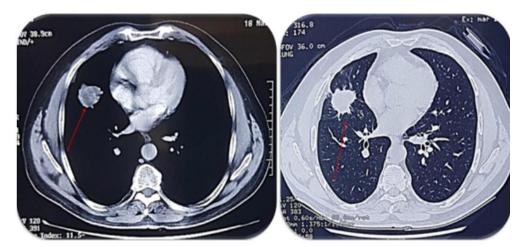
Chest CT scan demonstrating tissue injury with criteria for malignancy sitting on the right lower lobe in favor of a single metastasis.
